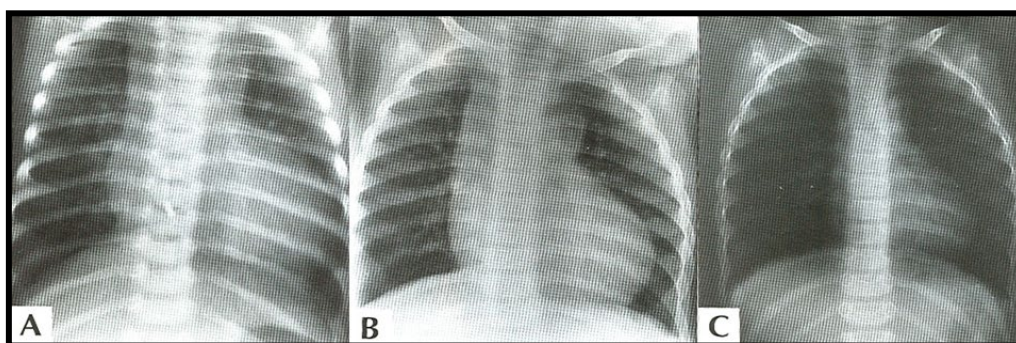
Serial chest X-rays in a tricuspid atresia patient with progressive diminution of the size of the ventricular septal defect, demonstrating a decrease in the size of the heart and of the pulmonary vascular marking. Reproduced from Reference 10.
